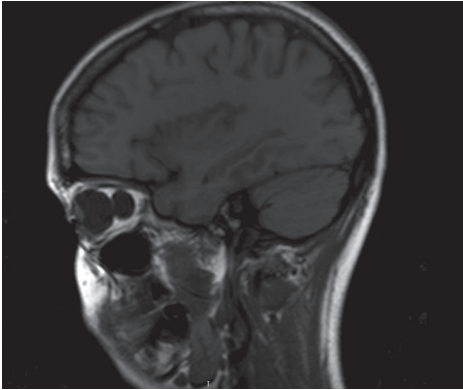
Postoperative sagittal MRI scan of the patient.
